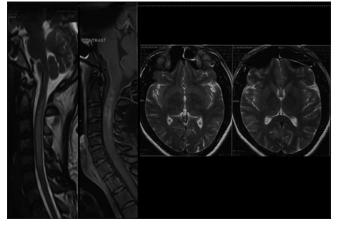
Magnetic resonance imaging of cervical spine showed longitudinal hyperintensity involving C1–C5 segments, with normal brain parenchyma
